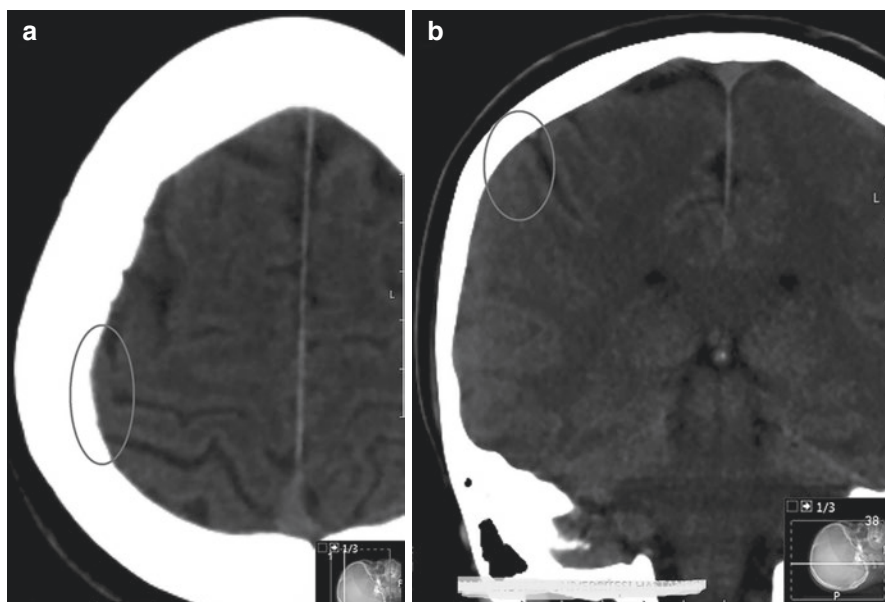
In axial non-contrast brain CT (a) isodense appearance that can mimic a subdural hematoma adjacent to the right central sulcus, it is understood to be cerebral parenchyma since it shows continuity with the adjacent gray-white matter in the coronal reformatted image (b)
